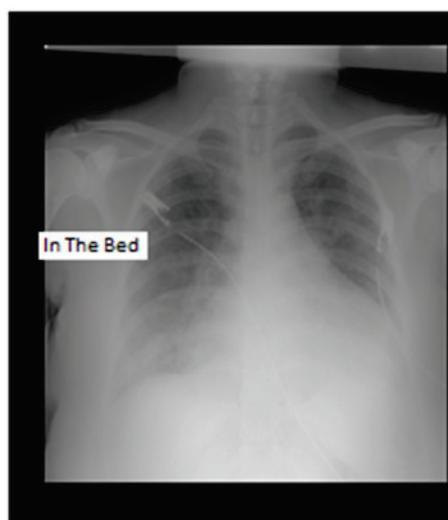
AP chest x-ray, CTR>0.50. Hyperdense areas in bilateral perihilar region and bilateral
